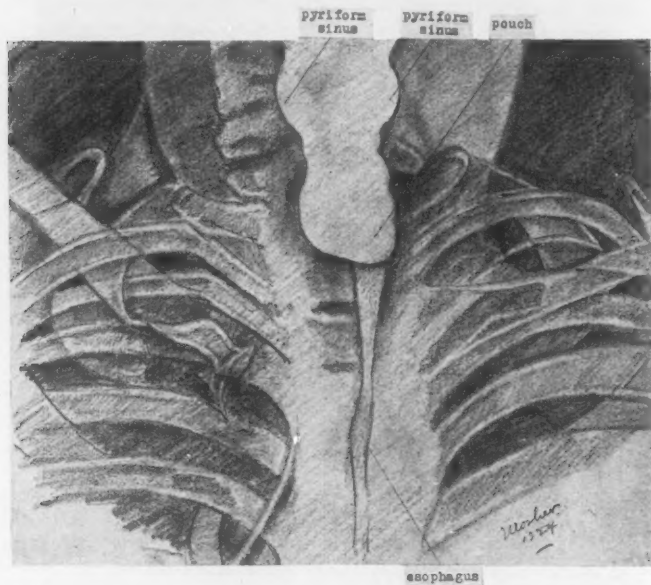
X-ray tracing of an esophageal pouch associated with asymmetry of the mouth of the esophagus. Notice that the esophagus runs down on the left side of the pouch. On examining the patient under ether it was found that the right half of the mouth of the esophagus was obliterated. Compare with Figs. No. 13-25. Patient seen through the courtesy of Dr. C. E. Cooper, of Denver. X-ray plate reproduced through the courtesy of Dr. L. G. Crosby, of Denver. Reduced one-half.
